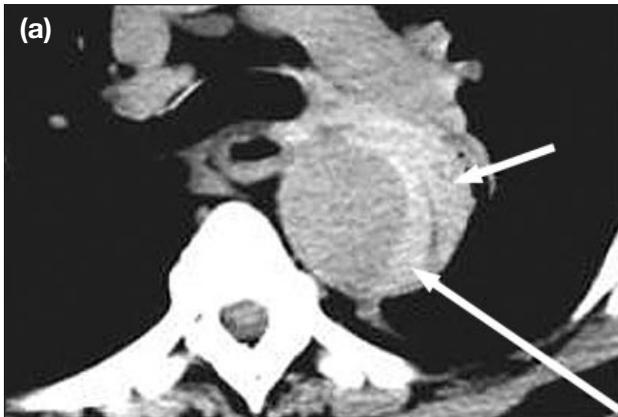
Spontaneous rupture of a penetrating atheromatous ulcer. (a) Axial non-contrast computed tomography obtained just below the aortic arch shows a crescentic intramural hyperdense haematoma (long arrow) and an adjacent hyperdense periaortic haematoma (short arrow); and (b) axial contrast-enhanced computed tomography obtained cranially shows multiple penetrating atheromatous ulcers (short arrows) seen as focal extensions of intraluminal contrast beyond the confines of the aortic intima. A periaortic haematoma (asterisk) and a large left haemothorax (asterisks) are also demonstrated.
